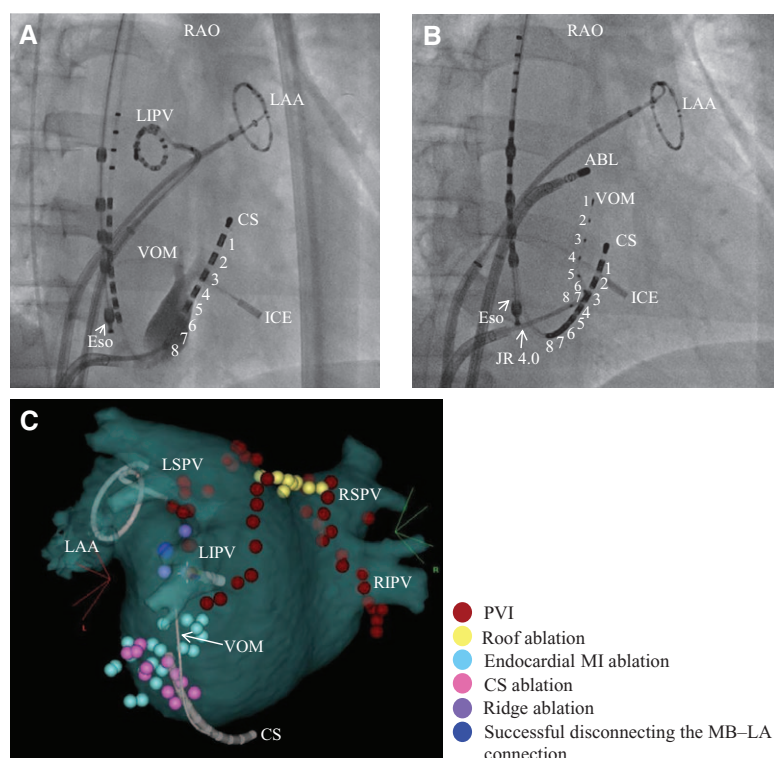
Catheter positions in fluoroscopy in the right anterior oblique (RAO) projection and 3-dimensional (3D) anatomic map of the left atrium. A, Fluoroscopic image shows the venography of the vein of Marshall (VOM). B, The 2F octapolar electrode catheter was positioned in the VOM using a 4F Judkins Right (JR) 4.0 guide catheter. At this point, the ablation catheter was positioned at the ridge. C, The 3D anatomic map shows the successful ablation site that was indicated by the blue dot. Radiofrequency catheter ablation was applied at this site and thereby successfully disconnected the Marshall bundle-left atrium (MB-LA) connection. ABL indicates ablation catheter; CS, coronary sinus; Eso, esophageal temperature monitoring catheter; ICE, intracardiac echocardiography catheter (SoundStar catheter, Biosense Webster Corp., Diamond Bar, CA); LAA, left atrial appendage; LIPV, left inferior pulmonary vein; LSPV, left superior pulmonary vein; MI, mitral isthmus; PVI, pulmonary vein isolation; RIPV, right inferior pulmonary vein; and RSPV, right superior pulmonary vein.
